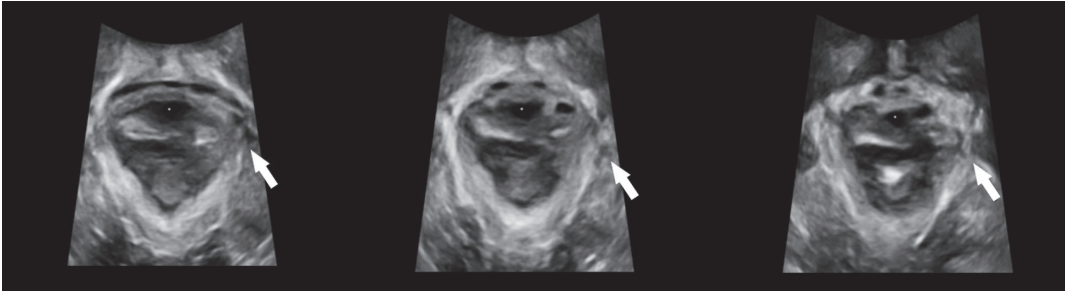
Left sided levator ani muscle (LAM) injury (white arrow) on tomographic ultrasound imaging at maximal levator contraction. Intact LAM on the right side
